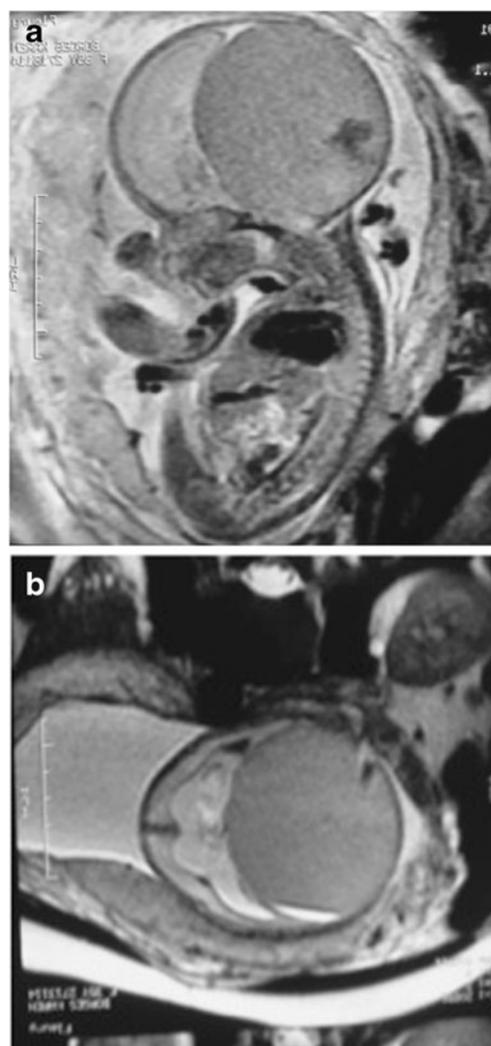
a Fetal MRI at 26 gestational weeks showing a giant aneurysm of Galen's vein with cardiomegaly. b Axial MRI showing occupation of more than half the cranial cavity by the aneurysm
